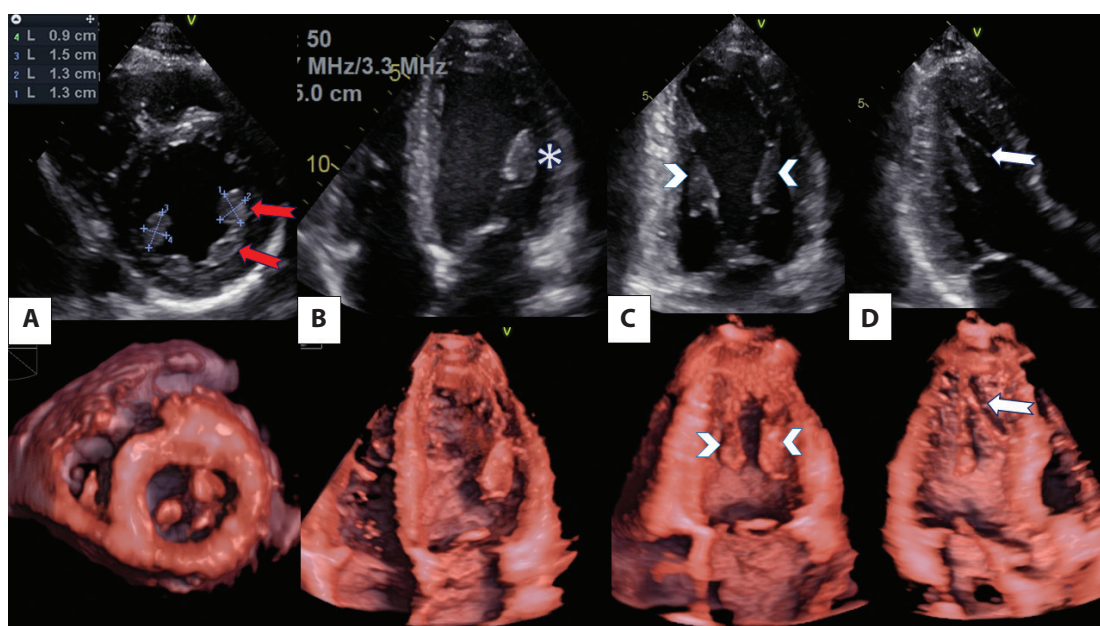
Comparative 2D and 3D transthoracic echocardiogram images (top and bottom panels respectively). A. Parasternal short-axis view demonstrating the measurement of papillary muscles and a double headed anterolateral papillary muscle (red arrows). B. Apical 4-chamber view showing the prominent anterolateral papillary muscle (asterisk). C. Apical 2-chamber view showing the hypertrophied papillary muscles (arrowheads). D. Apical 3-chamber view demonstrating a false chordae tendineae (white arrow)
